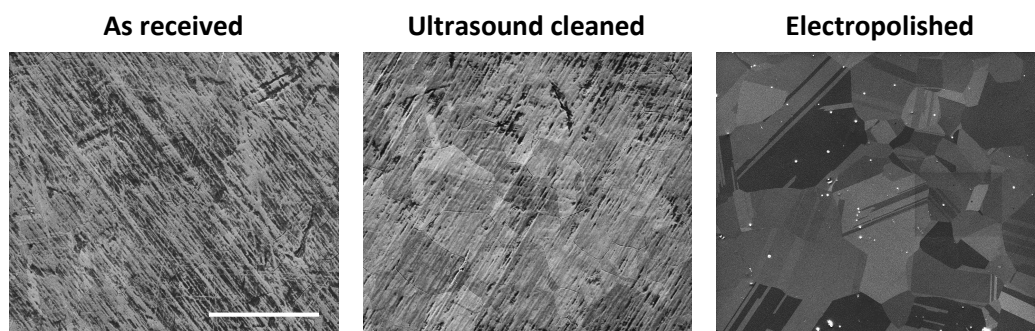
SEM pictures of CoCr samples after different surface treatments. Scale bar = 100 μm . Scratching grooves are visible on the “as received” and ultrasound cleaned samples, as a result of the mechanical polishing performed by the manufacturer. Black streaks, identified as organic contaminants, are present in the grooves, in particular on the “as received” sample. The grain structure is weakly visible on the ultrasound cleaned sample, and indiscernible on the “as received” sample. On the electropolished sample, the surface appears perfectly flat and free from grooves and organic contaminants. The grain structure is revealed, as well as some inclusions.
